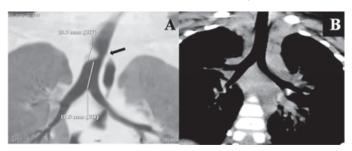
(A): CT thorax showing tracheal narrowing. (B): Post-operative CT thorax with normal tracheal lumen after 3 months
